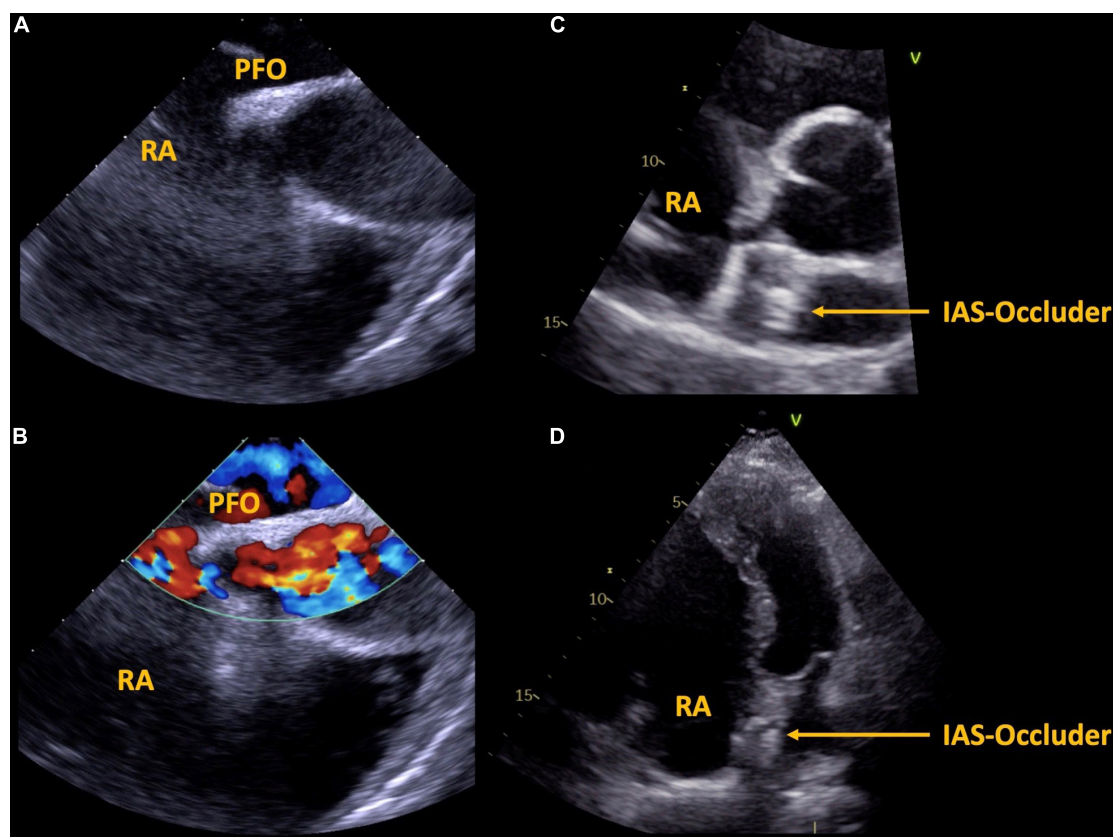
Case 2, 57 year-old patient with Ebstein's anomaly. A large PFO is shown via transesophageal echocardiography without (A) and with (B) color Doppler imaging. Interventional septal occluder implantation was performed, the result is shown in panels (C,D). PFO, patent foramen ovale, IAS, inter atrial septum, RA, right atrium.
